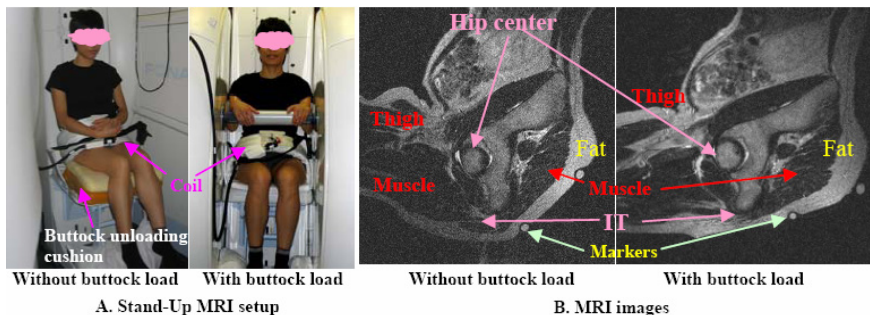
Open (Stand-Up) MRI (Upright™, FONAR Corp., Melville, NY) setup to record buttock-thigh structure under sitting load. MRI images corresponding with and without buttock sitting load are shown.
